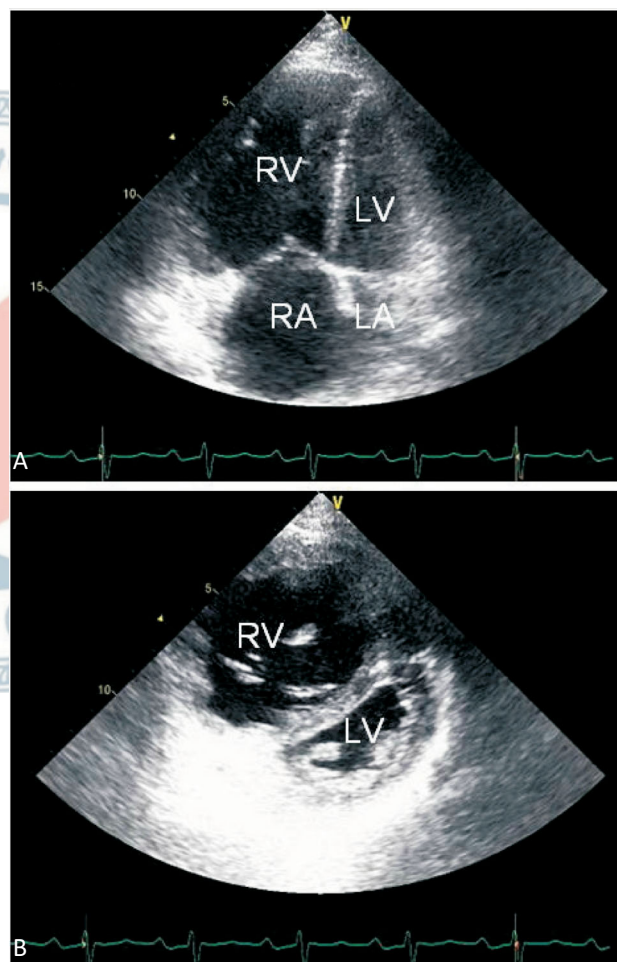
Two-dimensional echocardiographic features of patients with pulmonary arterial hypertension in apical 4-chamber view (A) and parasternal short-axis view (B). Common findings include right atrial and ventricular enlargement, thickening of the right ventricular free wall, flattening of the interventricular septum with a D-shaped left ventricle, and a small left atrium and ventricle. LA, left atrium; LV, left ventricle; RA, right atrium; RV right ventricle.
